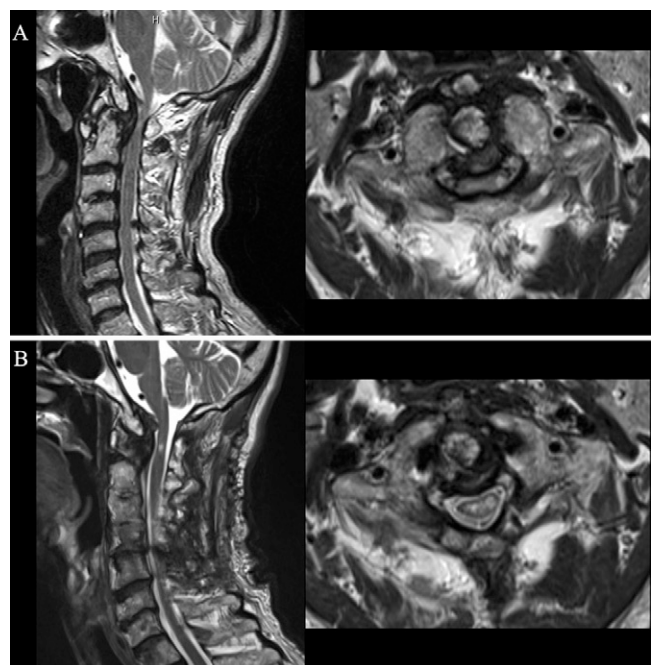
Preoperative and postoperative MRI. A: Preoperative MRI showed that the retro-odontoid pseudotumor compressed the cervical spinal canal and a high-intensity area within the cervical spinal cord on the T1-weighted image. B: Postoperative MRI revealed that the cervical spinal cord was adequately decompressed at the C1 level.
